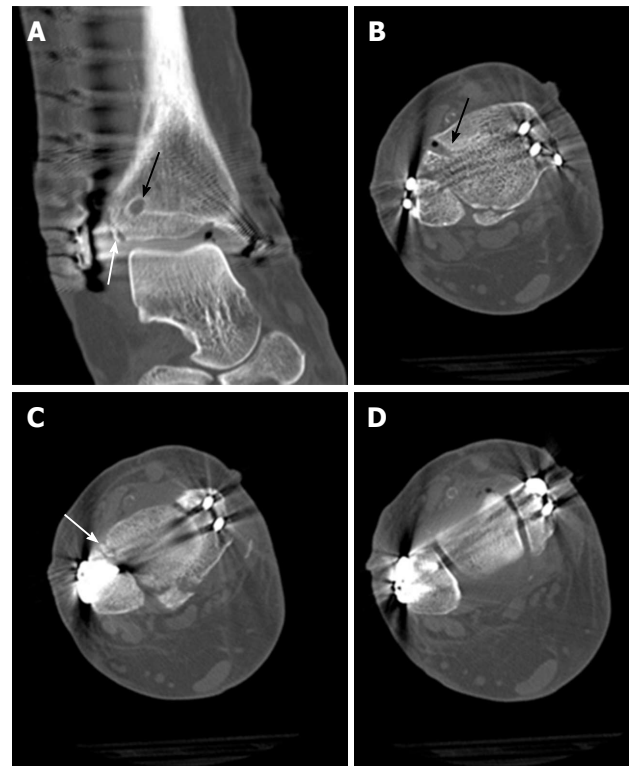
Postoperative computed tomography scans of the ankle from Figure 8 showing anatomic reduction of the tibial avulsion (white arrows) of the anterior tibiofibular ligament (A, C) as well as anatomic reduction of the ankle mortise (D); the tibial bone tunnel (black arrows) for the *InternalBrace*™ is clearly visible (A, B).
